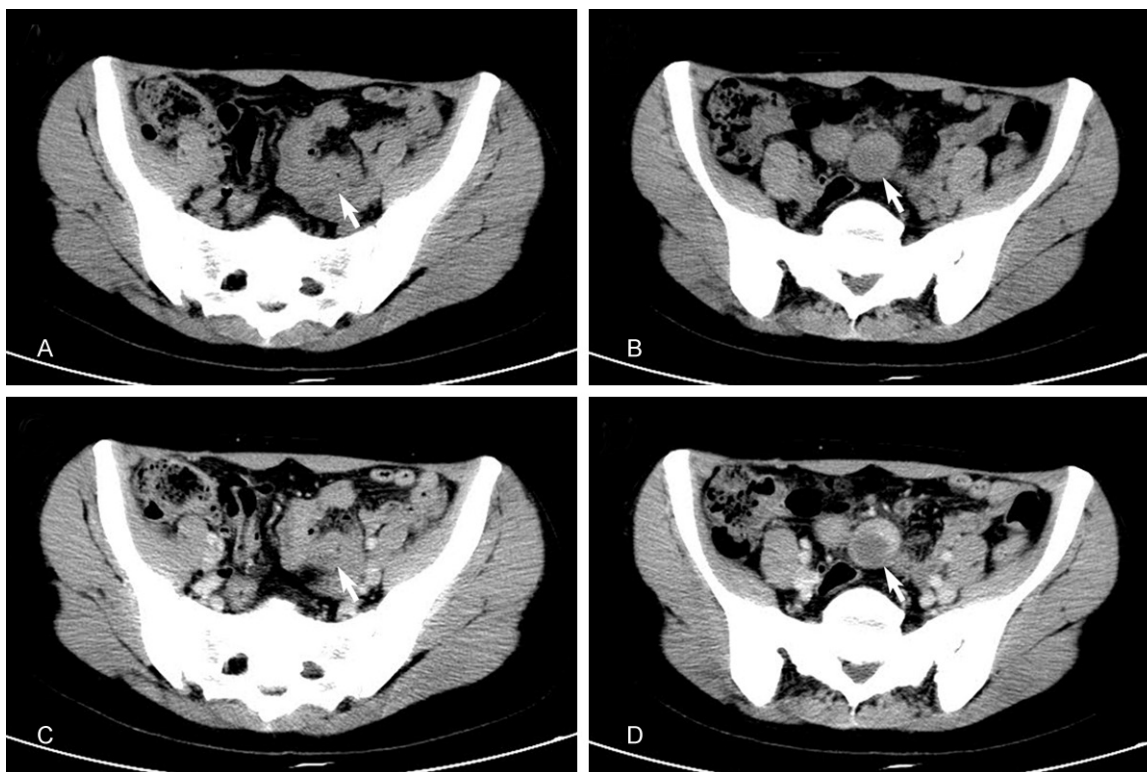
CT images of PBL in the ileum of a 33-year-old female. A. Plain CT scan shows a mass in small intestine (white arrow); B. Plain CT scan shows enlarged lymph node in the retroperitoneal regions (white arrow); C. Venous phase enhanced CT scan shows the mass (white arrow); D. Venous phase enhanced CT scan shows the enlarged lymph node with low density in the center (white arrow). CT, computed tomography.
